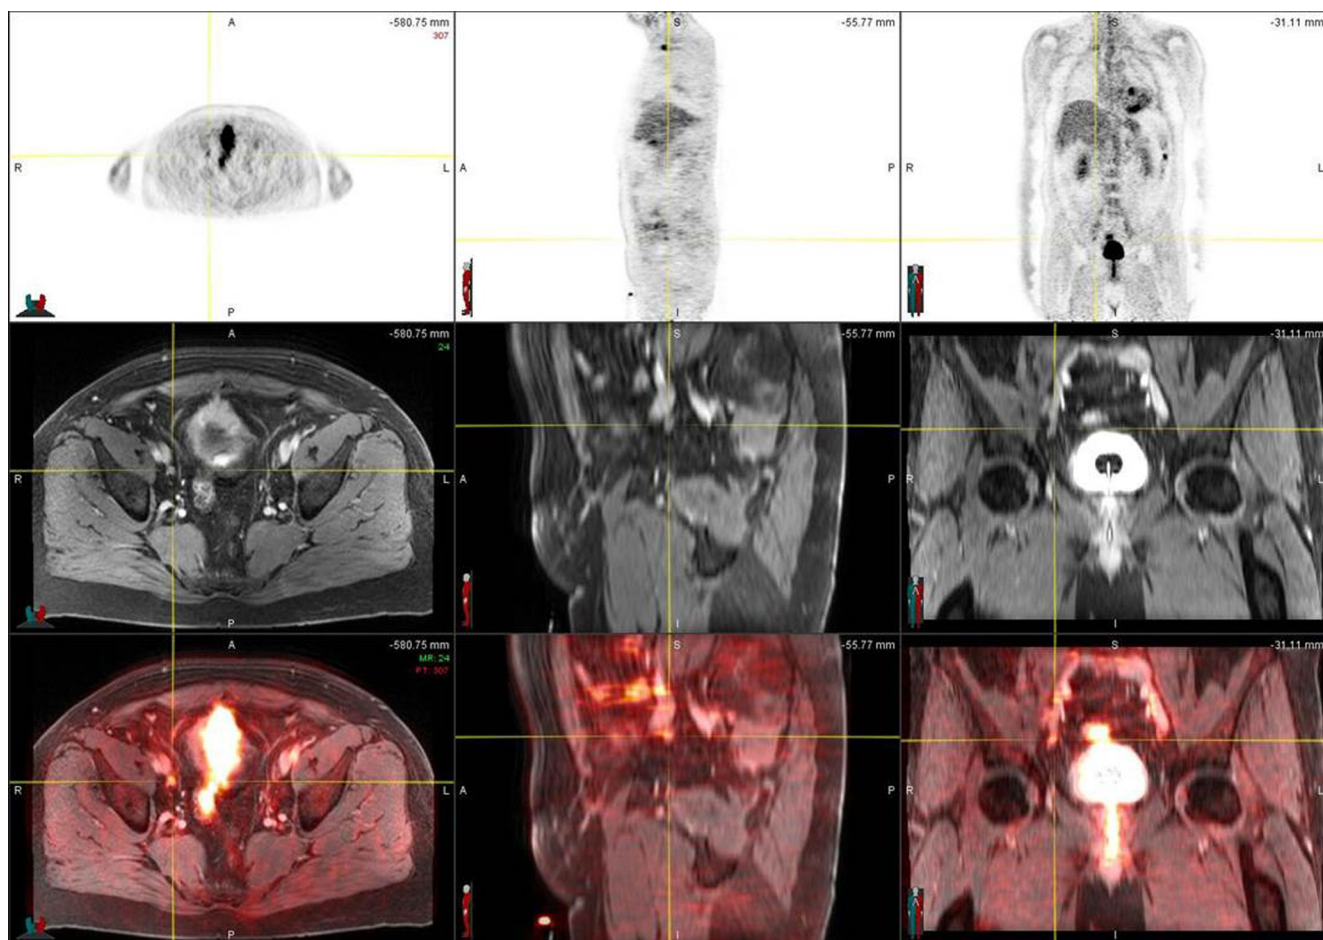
Fused MR/PET in a 72-year-old male with bladder cancer. The cross hairs are placed on a right external iliac metastatic lymph node. Row 1 shows PET scan, there is no increased uptake to suggest metastatic disease. Row 2 shows contrast-enhanced MRI with enhancement of the bladder and vessels. Again, the lymph node shows minimal enhancement.
